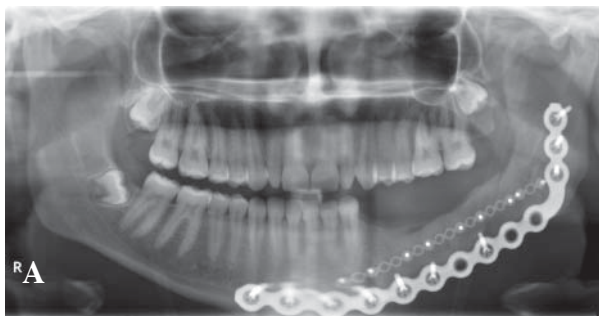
A 19-year-old female who underwent an iliac crest bone graft reconstruction immediately after the excision of an ameloblastoma. A. Preoperative panorex showing the ameloblastoma in her left posterior mandible, B. & C. Preoperative CT scan viewed in Simplant® software revealing the dimensions of the tumor, D. Digitally reconstructed panorex showing extent of tumor, E. Three-dimensional reconstruction showing the extent of the tumor, F. Stereolithographic model (Medical Modeling®) fabricated from CT scan data with a mandibular reconstruction plate (Stryker-Liebinger®).
